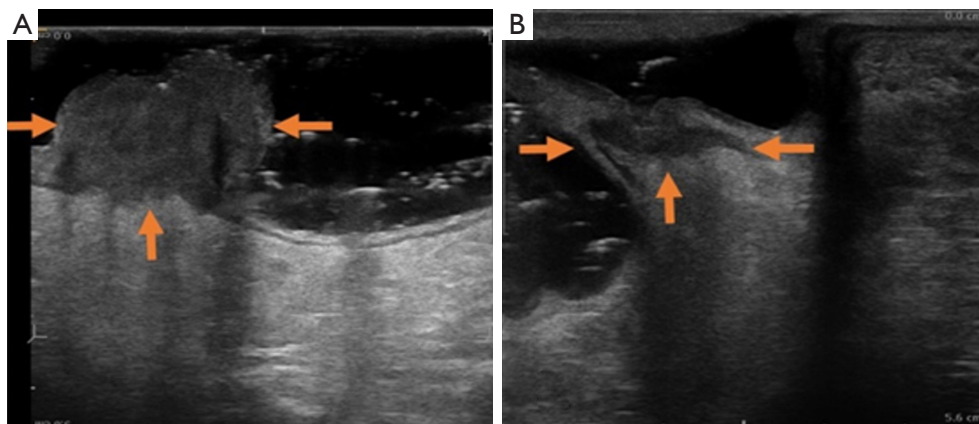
False negative findings in a 59-year-old man with pCR. (A) Pre-CRT T-staging of rectal cancer (orange arrows) by 3D-ERUS was T3. (B) Restaging of lesion after CRT by 3D-ERUS remained T3 but the pathological result turned out to be T0N0 (pCR). Fibrosis and inflammation induced by CRT was presented as hypoechoic lesion (orange arrows) and can be confused with carcinoma. pCR, pathological complete response; CRT, chemoradiation therapy; 3D-ERUS, three-dimensional endorectal ultrasound.
